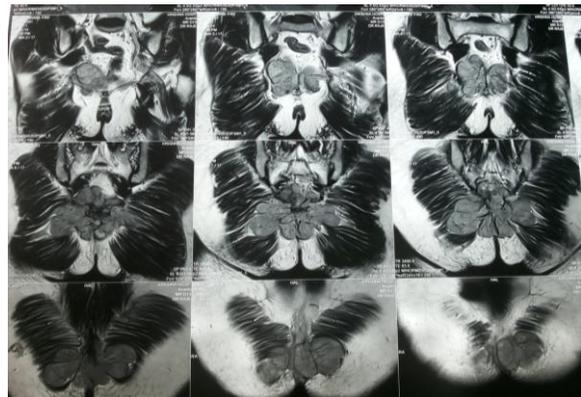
(MRI coronal section sacrococcygeal region)
